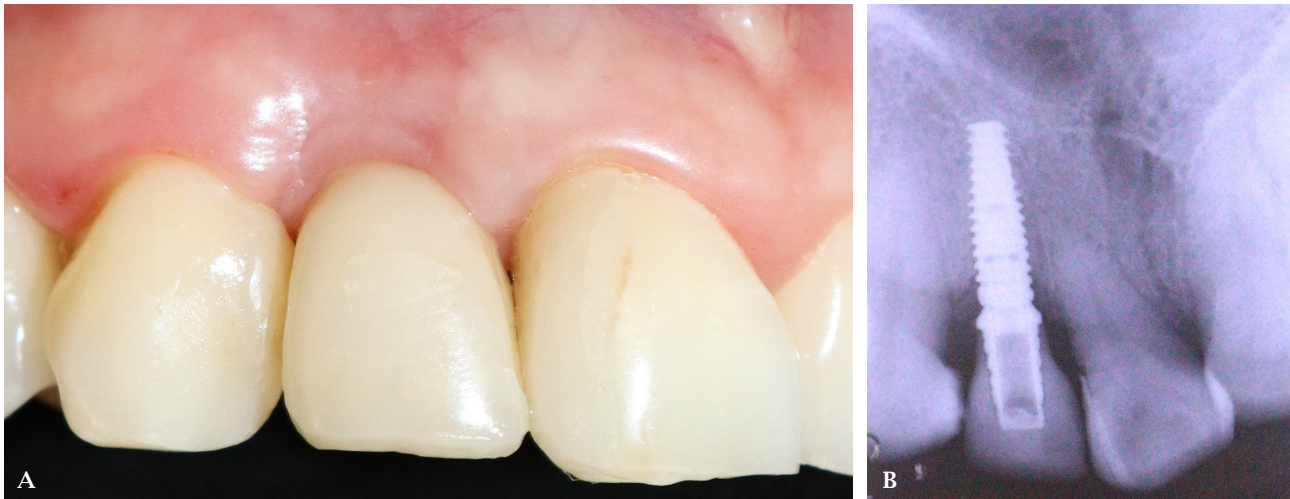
A) Fourteen months follow-up. B) Radiograph at 14 months.
